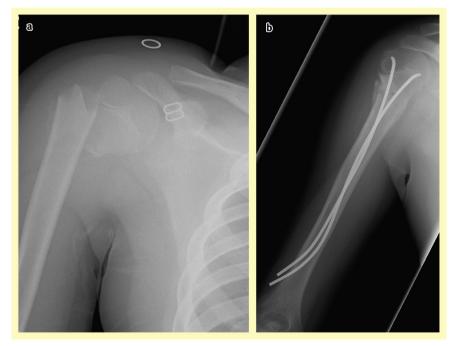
(a) Pre- and (b) postoperative radiographs of a displaced humeral fracture, treated with intramedullary nailing.
